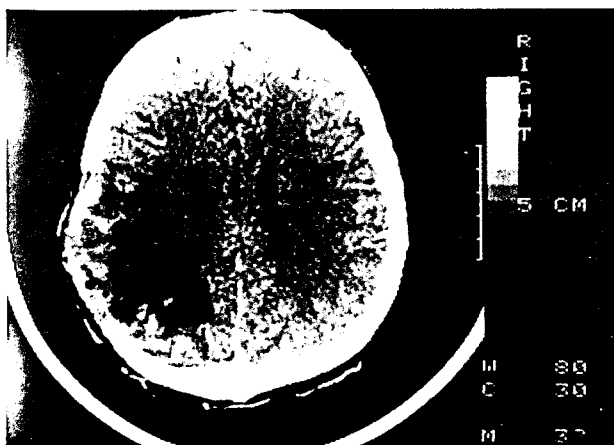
Contrast-enhanced CT scan shows a large, irregular, extending area of hypodensity. A small foreign body is seen. Cerebritis (Case 8).
